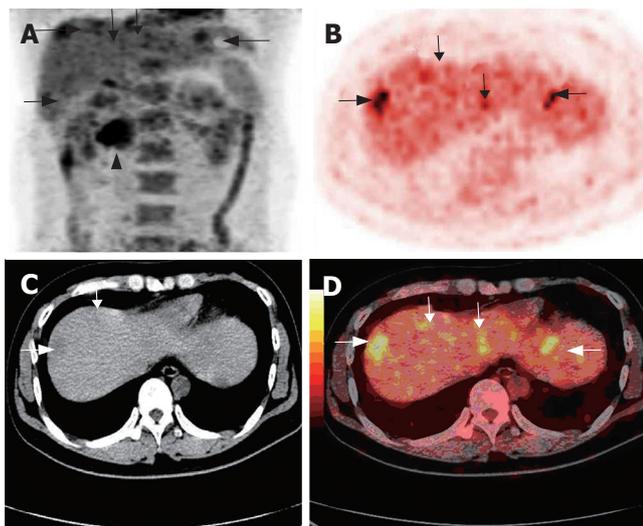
A 33-year-old man undergoing ascending colon cancer resection two years ago. Coronal PET image (A) also showing recurrent lesion (arrow head) at the root of mesentery, ^{18}F -FDG PET (B) and PET/CT fused imaging (D) demonstrating multiple hepatic metastases (arrow), and non-enhanced CT (C) detecting fewer lesions than PET/CT fused imaging (D).
